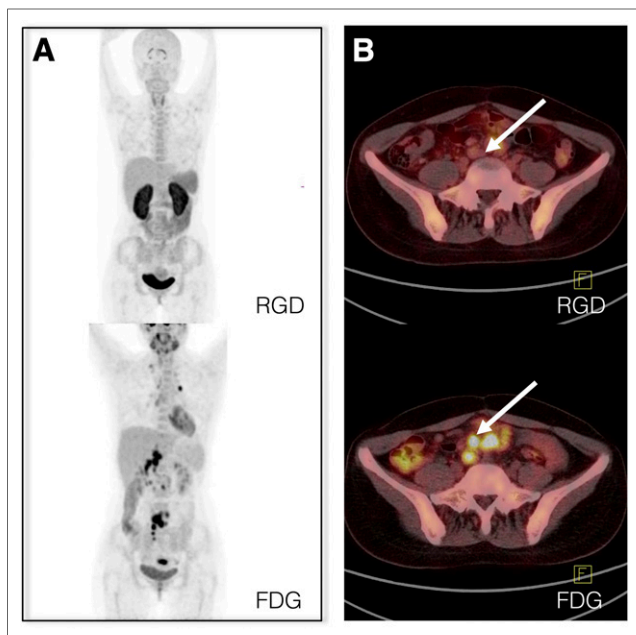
^{18}F -alfatide and corresponding ^{18}F -FDG PET/CT scans of scrofula patient (patient 10 in Table 1). (A) Maximum-intensity-projection PET images of scrofula patient at 1 h after injection of ^{18}F -alfatide (upper) and ^{18}F -FDG (lower). (B) Transaxial PET/CT fusion image covering intestine. Negative uptake at 1 h after injection of ^{18}F -alfatide (upper) and high uptake in scrofula patient at 1 h after injection of ^{18}F -FDG (lower) are shown. Arrows point to tubercular lymph nodes.
